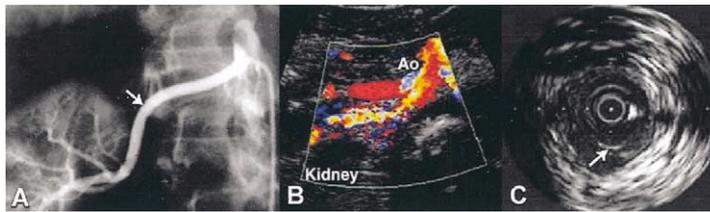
(A) Right renal artery angiogram with subtle irregularities at the edges of the arterial lumen, producing a slightly scalloped appearance. (B) Transverse view at the level of the origin of the right renal artery showing laminar flow in the proximal segment (red), becoming turbulent in the middle segment, beginning with the first curve on the angiogram. (C) Intravascular ultrasound in the middle segment of the right renal artery, demonstrating a membrane (arrow). Ao = aorta.
